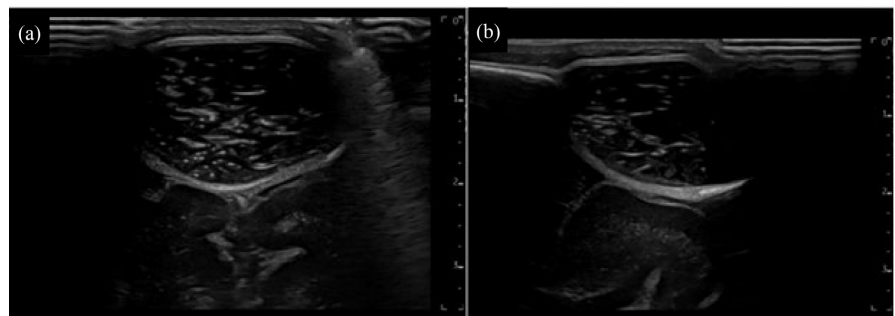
Scalp ultrasound: extracranial subgaleal fluid-filled mass over the sagittal sinus containing multiple linear and punctiform echogenic structures on transverse (a) and longitudinal (b) views.
